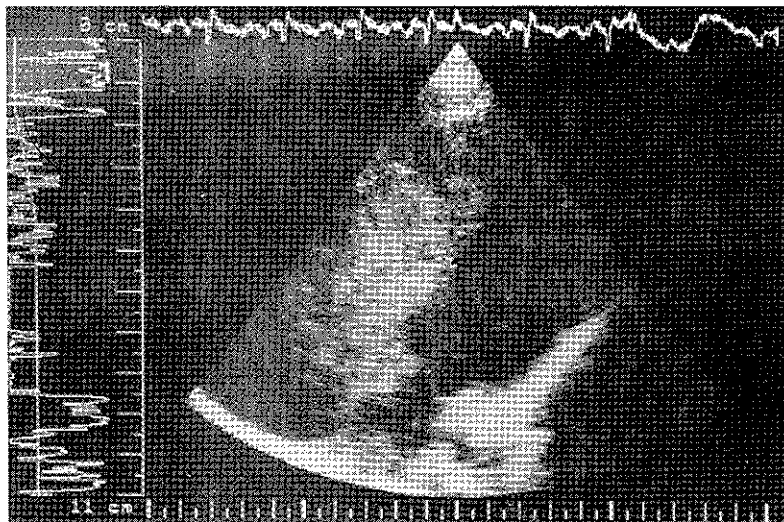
M-mode echocardiogram showed a large tumor mass (arrow) that came to the right ventricle in diastole
